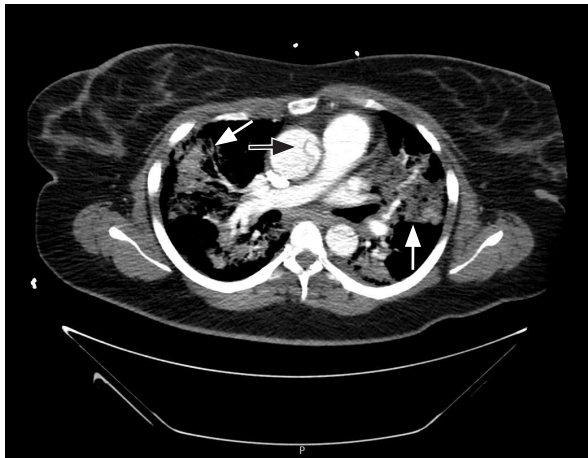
Aortic computed tomography angiography shows an intimal flap in the ascending aorta; patchy opacities are visible in both lungs.
